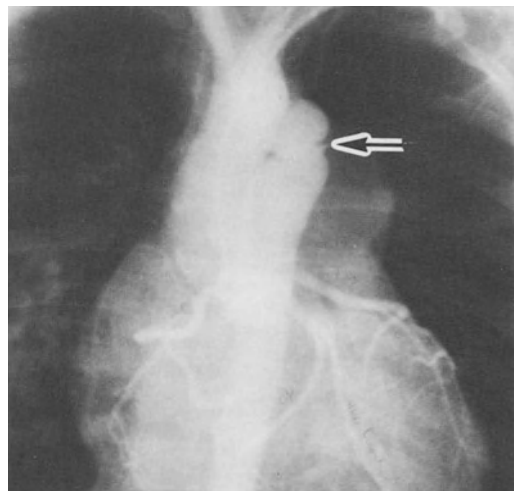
Chest X-ray (left) in a case of large ventricular septal defect and large left-to-right shunt associated with coarctation of the aorta demonstrated by angiography. (right)
